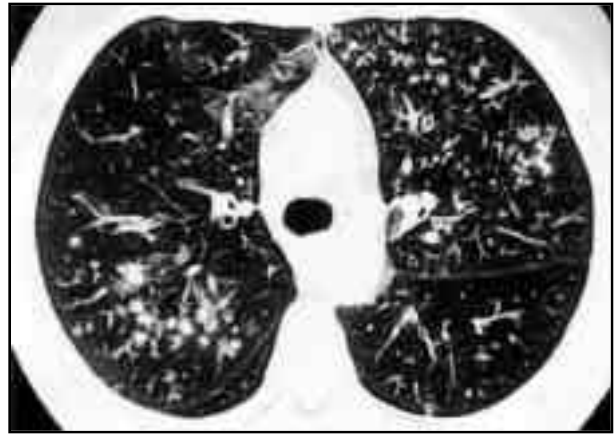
HRCT of case 1 showing centrilobular nodular opacities (thin arrows) and branching linear opacities (thick arrow) (tree-in-bud pattern)
